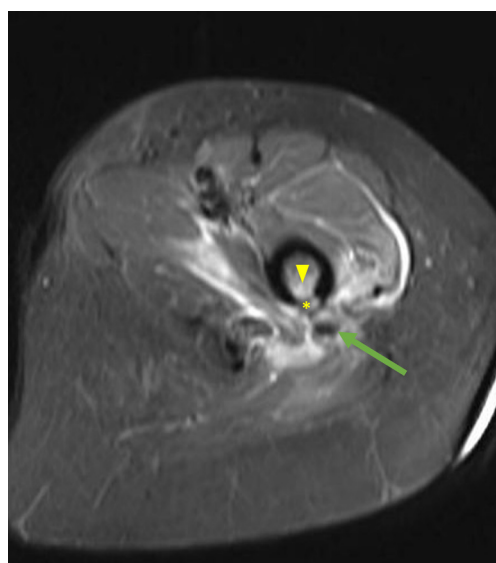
Axial T2-weighted MRI image of the left upper thigh, obtained a few days after symptom onset, demonstrates extensive deep soft-tissue oedema adjacent to the posterior femur, a focal hypointense lesion (green arrow), cortical interruption (yellow asterisk), and mild endosteal bone marrow oedema (yellow arrowhead).
